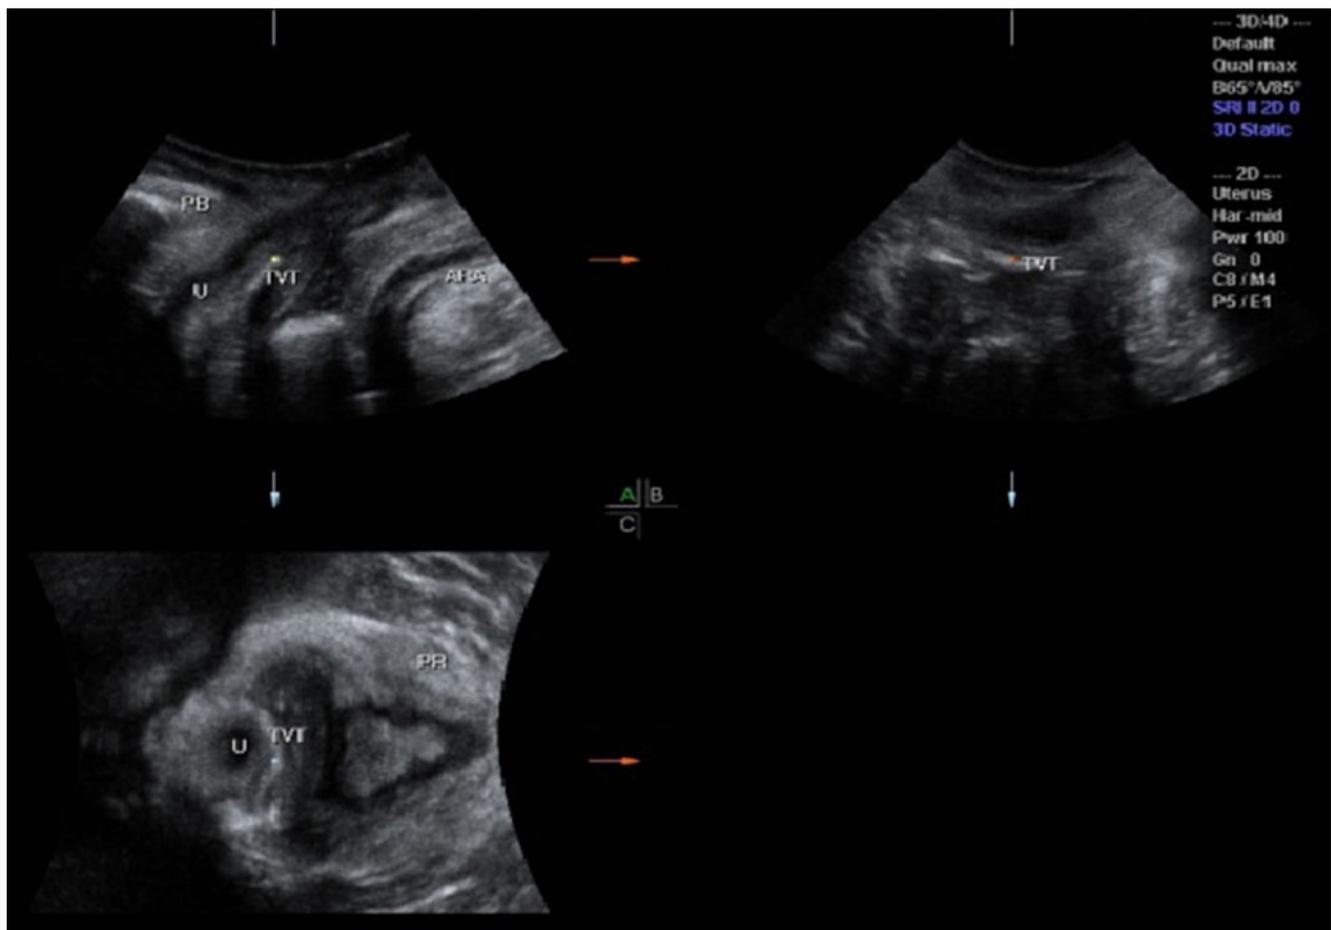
Three-dimensional ultrasound pelvic floor image of a 56-year-old woman following TVT insertion. The tape is shown as a hyperechogenic structure underneath the mid-urethra in the sagittal
